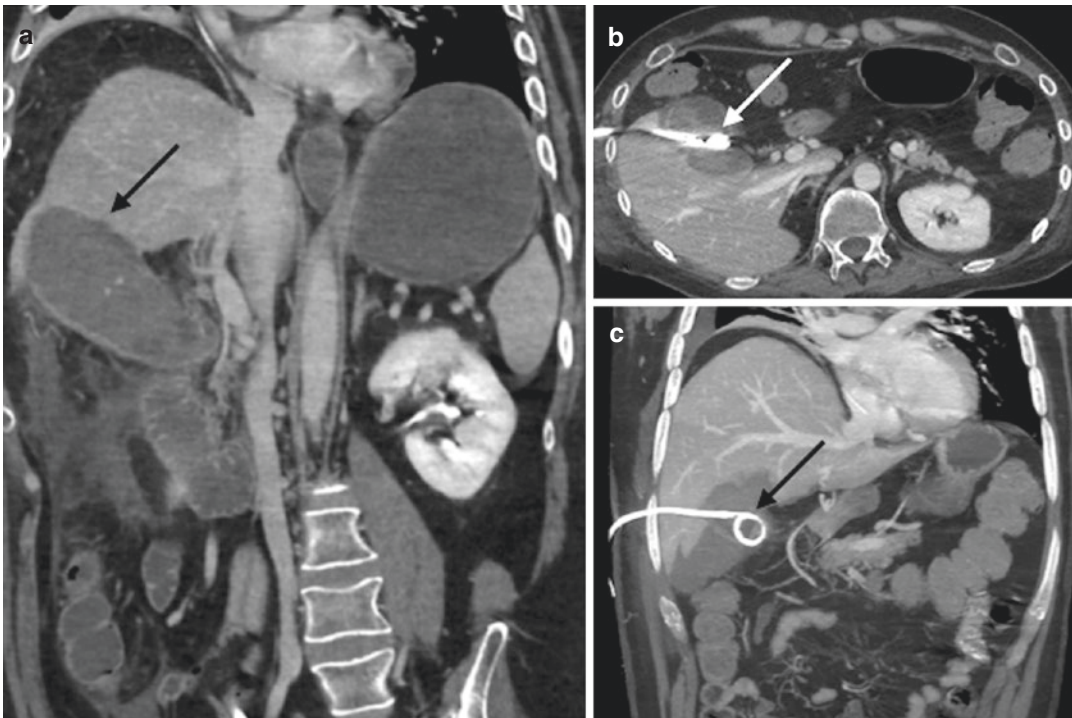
Emergency CT examination of 74 patients with acute cholecystitis in coronal view (a). Note the distended gallbladder with irregular and inhomogeneous wall enhancement (a, arrow). As the patients could not
